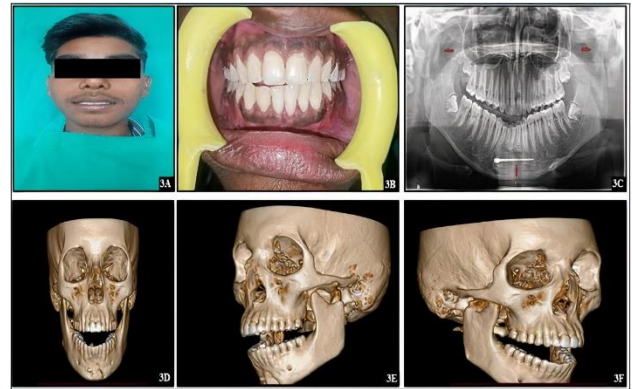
A and B: Postoperative assessment showing improved facial lower third height and symmetry with stable normal occlusion. (C) Postoperative OPG after a month showing lag screw in position and functional remodelling of the condylar process. (D) Postoperative CT scan showing lag screw in place. (E and F) Left and right CT scan showing remodelling of condylar process of mandible.
